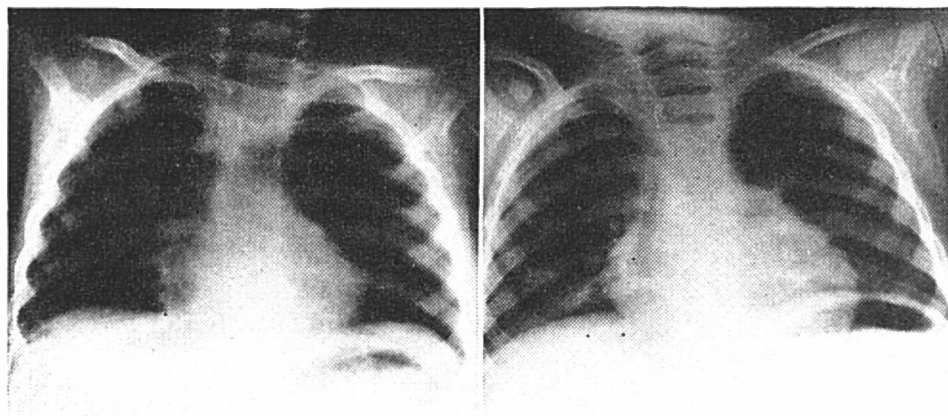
Anterior-posterior roentgenogram of thorax in boy 2 years, 7 months of age upon admission (*left*) and with initial recovery well advanced after 14 days of dietary therapy (*right*). Photographs indicate an increase in relative size of heart with treatment.
